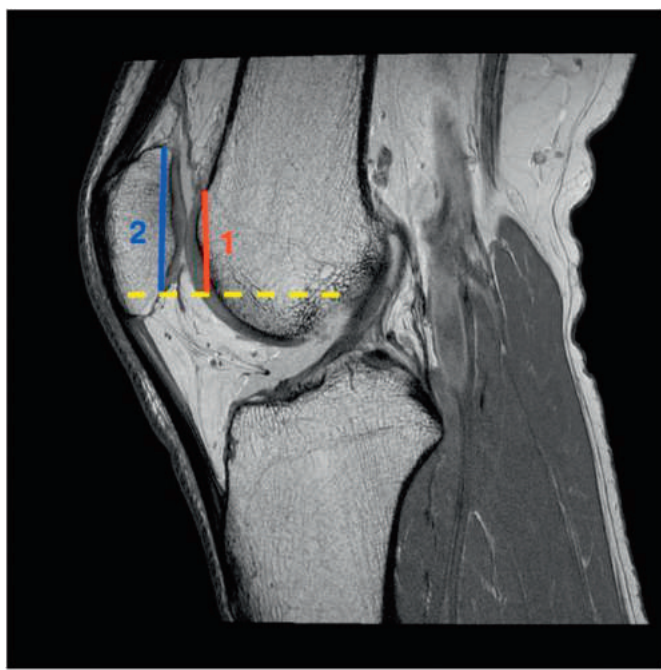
The patellochlear index (PTI) is calculated from the sagittal MRI slice with the maximum patellar cartilage thickness and the maximal craniocaudal diameter of the patella. Line 1 is divided by line 2 to create a ratio. Normal range is 0.12–0.50 with less than 0.12 representing patella alta.
